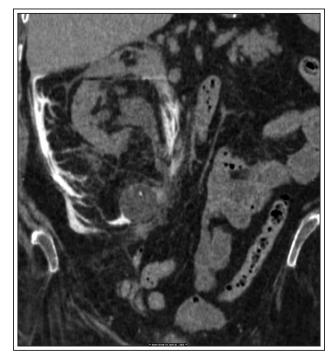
Coronal CT image demonstrates spherical foley catheter balloon in the region of the proximal right ureter, hydronephrosis, and contrast in the right pararenal space.
